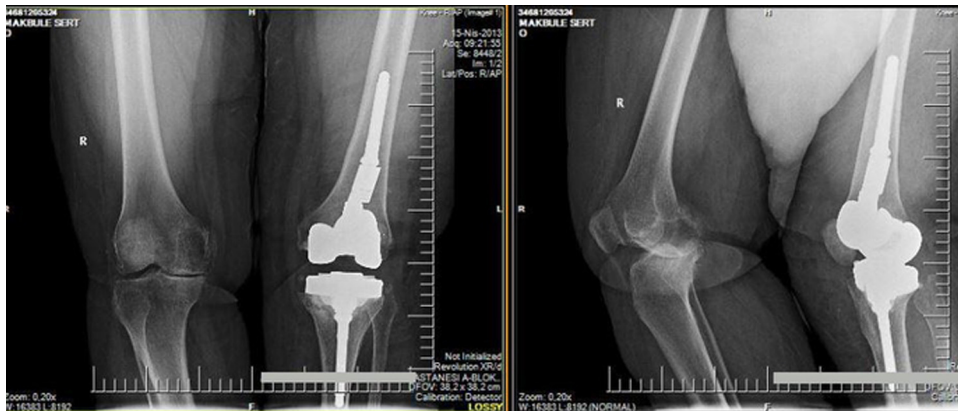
Postoperative AP and lateral radiographs after the revision knee arthroplasty.
